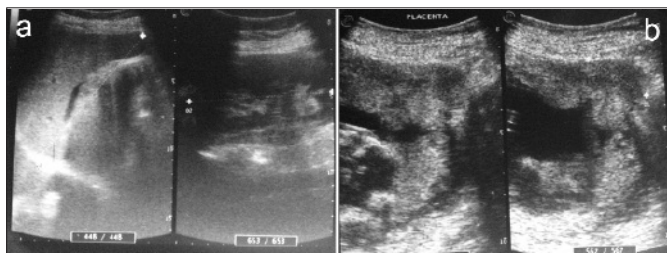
(a) Ultrasound image showing echogenic free fluid around the spleen, (b) Ultrasound image showing a part of placenta growing outside the uterus.
